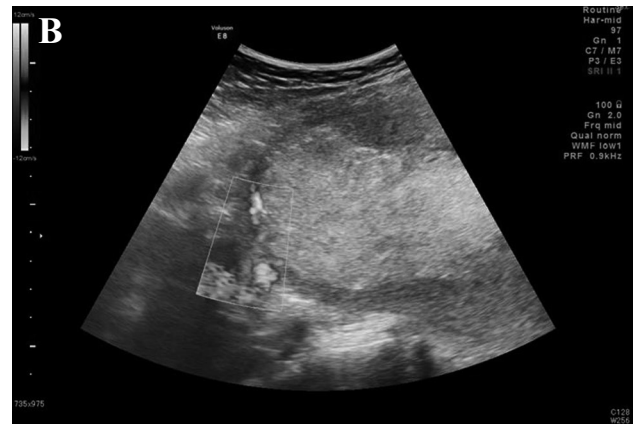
A) MRI on the 30th day postpartum showing an extremely thin fundal myometrium (Case 2). B) Transabdominal US showing the presence of blood flow between the myometrium and the retained placenta (Case 2).
